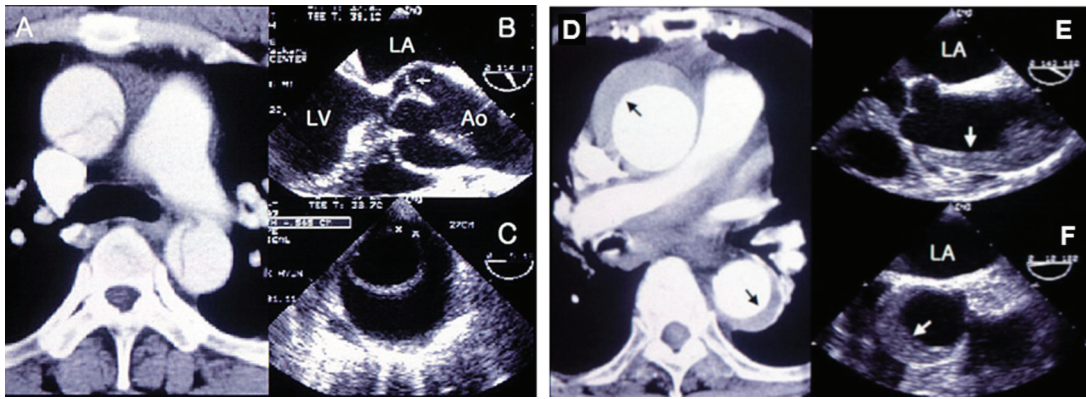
Representative computed tomography and transesophageal echocardiography images of classic aortic dissection (A–C) and intramural hematoma (D–F). Reproduced from Ref. [2] with permission.
